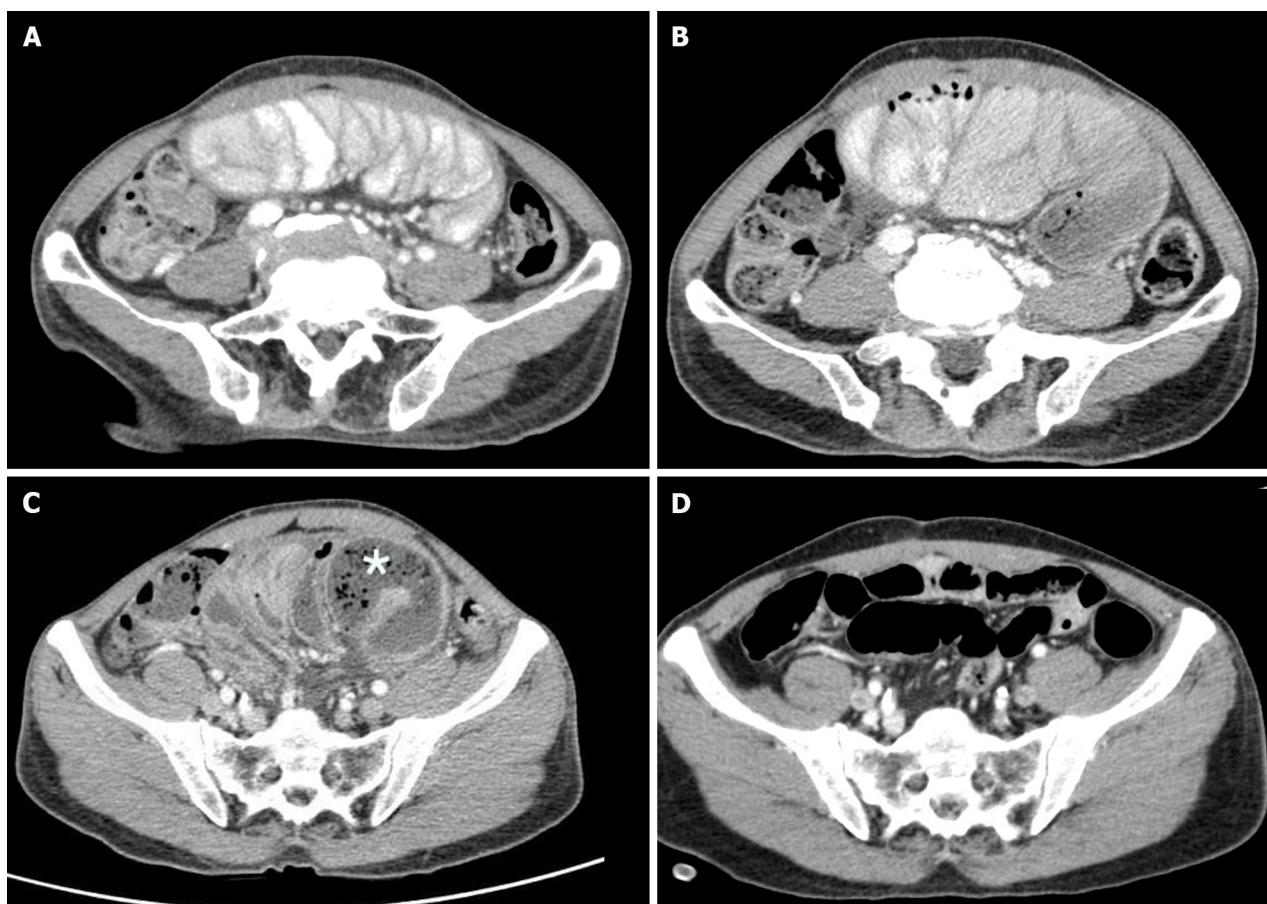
Computed tomography scan whole abdomen with contrast. A and B: Stacking small bowel loops inside a thick membrane-like sac; C: Small bowel feces sign (asterisk); D: Normal alignment of the small bowel after operation.
